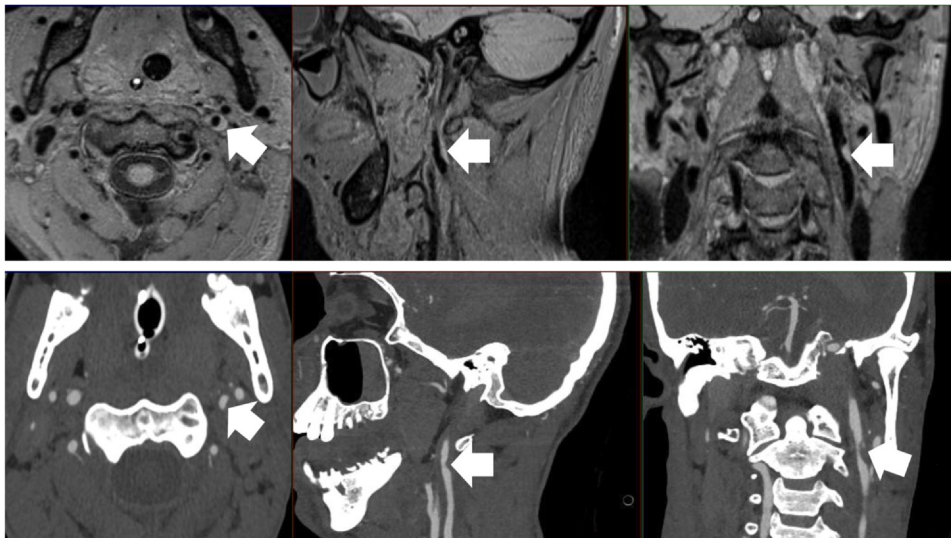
Carotid dissection: axial view shows eccentric thickening. An occlusion is diagnosed by long hyperintense thickening of the wall best seen in the sagittal VWI as opposed to focal wall thickening of atherosclerosis. The hyperintense signal is also characteristic denoting thrombus/hemorrhage in the false lumen. Corresponding CTA images (bottom row) show similar indentation of the lumen. CTA computed tomographic angiography
